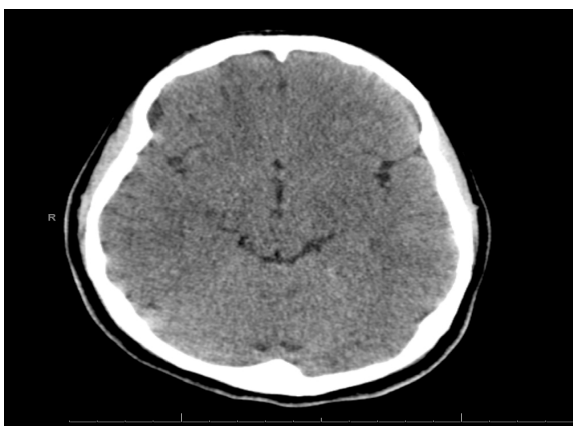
Normal brain computed tomography scan.
